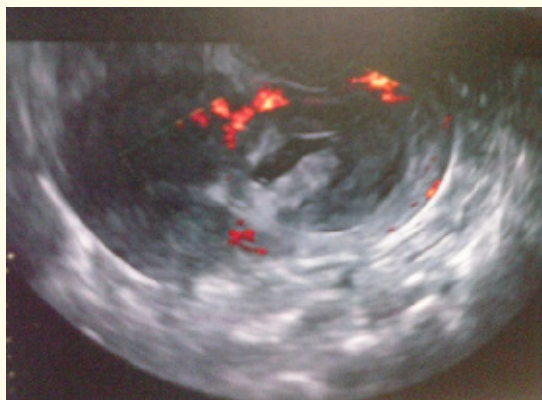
Transvaginal Color Doppler ultrasound image of cervical pregnancy at 8 weeks' gestation.
